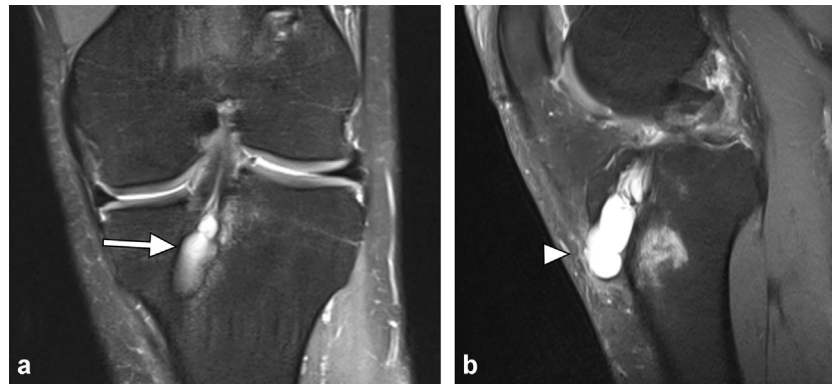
Cyst formation in the tibial tunnel (arrows) extending to the pretibial subcutaneous soft tissues (arrowhead). Coronal (a) and sagittal (b) fat-suppressed PD-weighted MR images.
